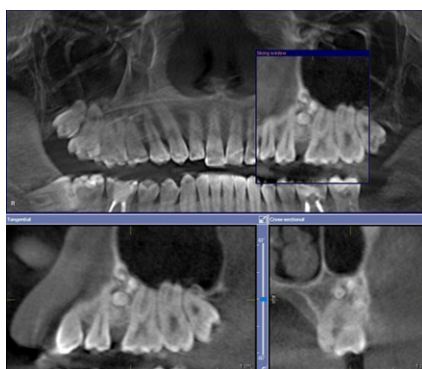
Multiplanar CBCT view showing compound odontoma of the maxilla.
